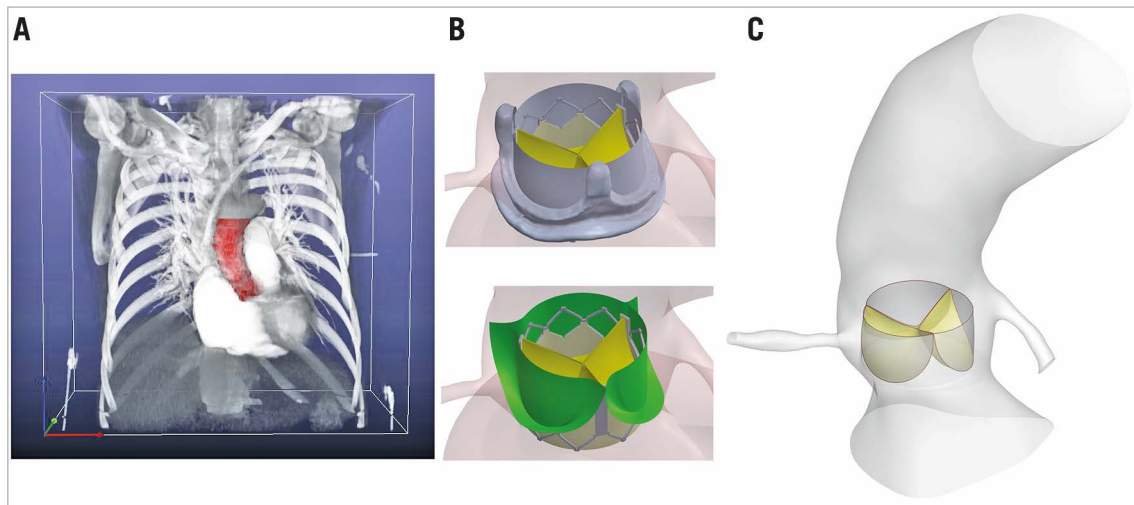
Patient-specific geometry. A) Construction of the 3D patient-specific geometry via processing of CTA images. B) TAV leaflets are confined by leaflets of the native valve in TAVI (bottom) and by leaflets and frame of the failed bioprosthesis in ViV (top). C) Simplified computational TAV model (Reprinted with permission from Vahidkhalil et al¹²). CTA: computed tomographic angiography; TAV: transcatheter aortic valve.
